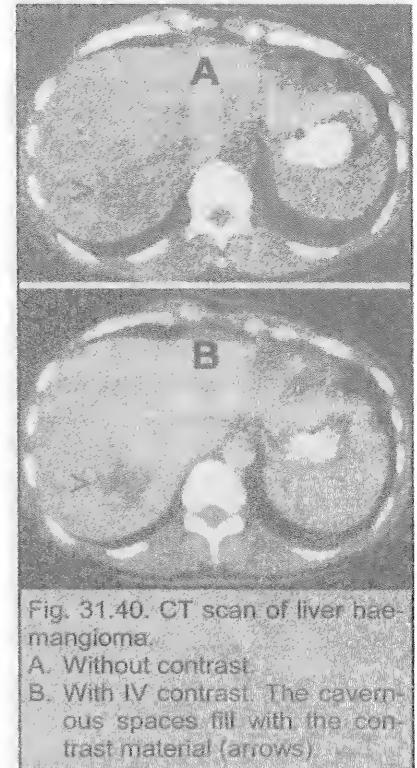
CT scan of liver haemangioma.
